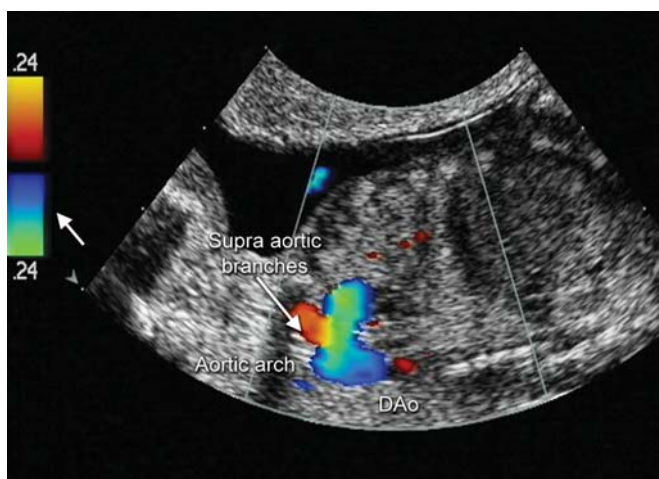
Early fetal echocardiography by 2D and color Doppler in a structurally normal heart. Color Doppler is particularly useful to demonstrate the aortic arch. DAo: descending aorta
